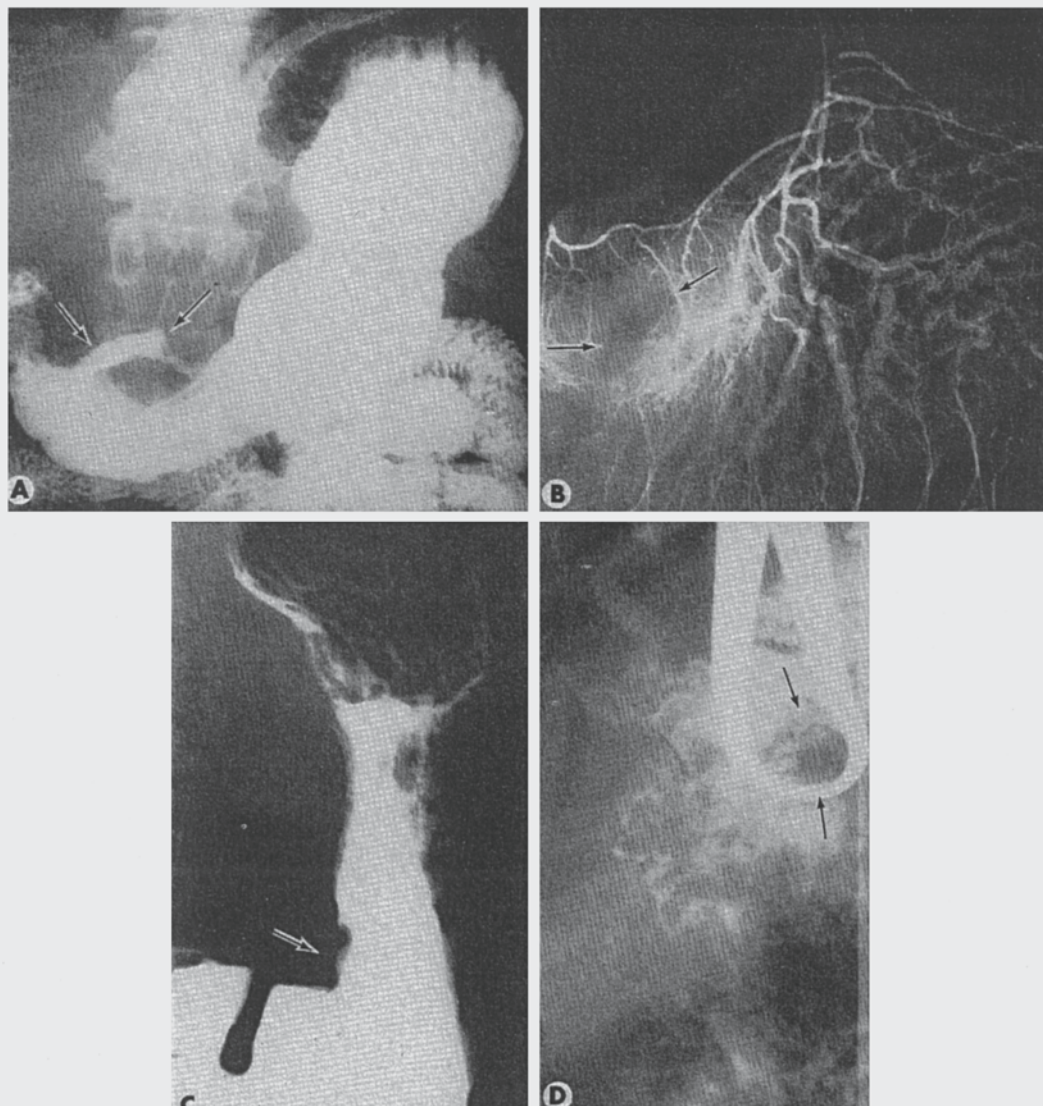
(A and B) Large ulcerative carcinoma of the stomach. (A) A roentgenogram of the upper gastrointestinal tract with barium. (B) Only few vessels are seen in the area involved by the tumor. There is a strong suggestion of some irregularity in the lumen of the many attenuated vessels. (C and D) Benign peptic ulcer of the lesser curvature of the stomach. (C) An upright roentgenogram of the barium filled stomach with the ulcer shown in profile (arrow). (D) An operative arteriogram. Numerous tortuous vessels surround the ulcer which is the radiolucent area (arrows). There is no evidence of perivascular opacity. (A metallic instrument was left in the field of exposure by error.)
